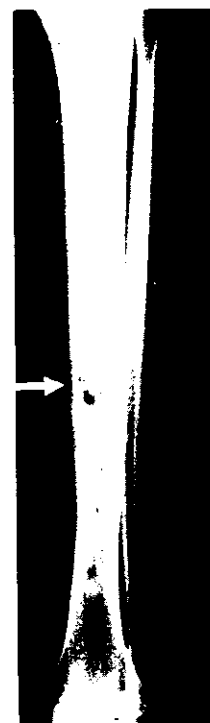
Case 2. A radiograph showing a larger aneurysmal bone cyst lesion involving the tibial mid-diaphysis. An arrowhead points to a central lesion at the upper end of the bone.
